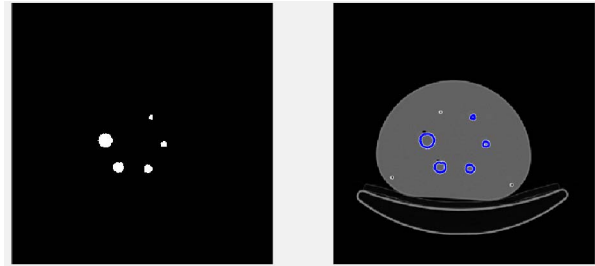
On the left side, there are visible identified tumours on the PET image. On the right side, in the CT image, there are visible contours marking all tumours.
